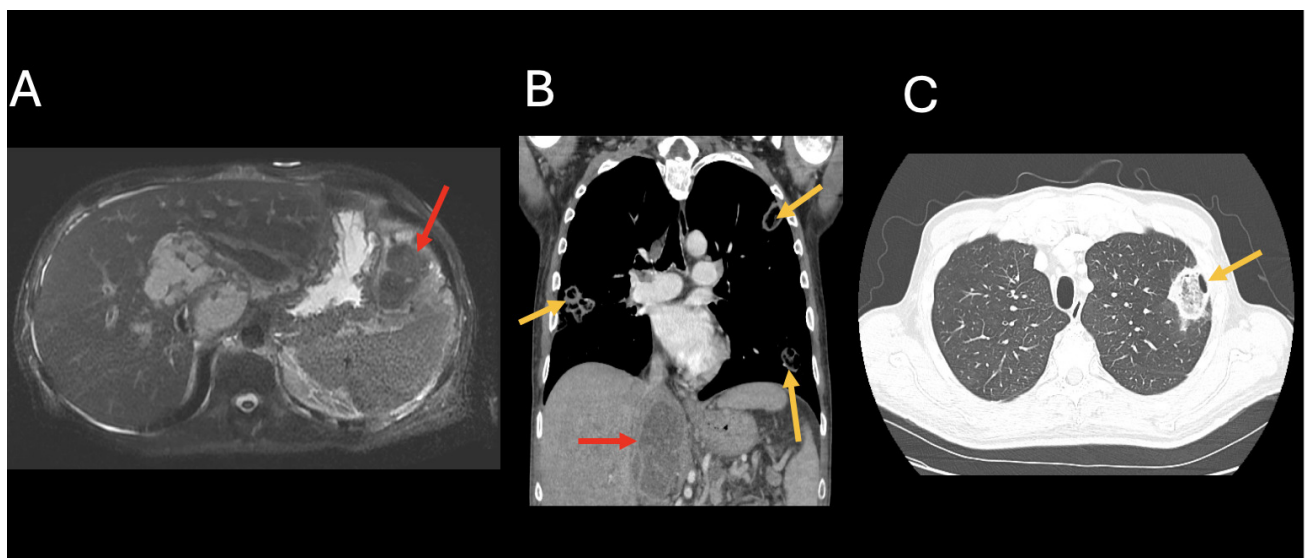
A: MRI with and without contrast showing a large multiloculated abscess in the caudate lobe of the liver (red arrow). B: CT Coronal view of chest revealing multiple cavitory pulmonary lesions (yellow arrows) and a large multiloculated abscess in the caudate lobe of the liver (red arrow). C: CT chest with IV contrast showing a left upper lobe cavitory pulmonary lesion abutting the pleura (yellow arrows).
